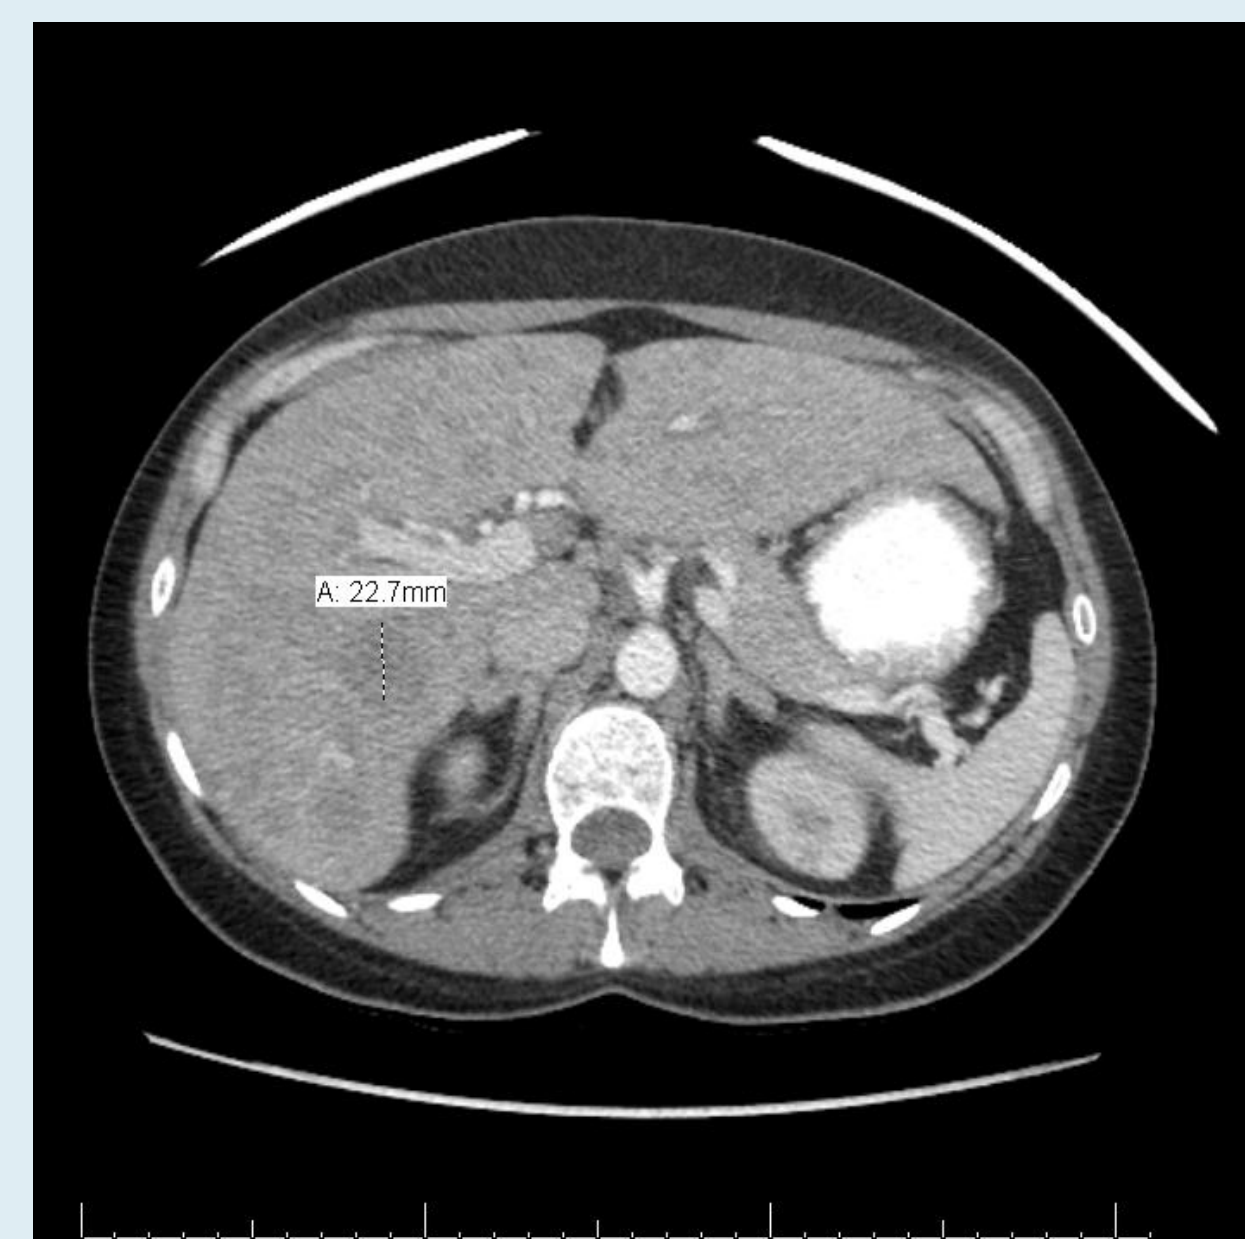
CT abdomen/pelvis showing liver metastases
